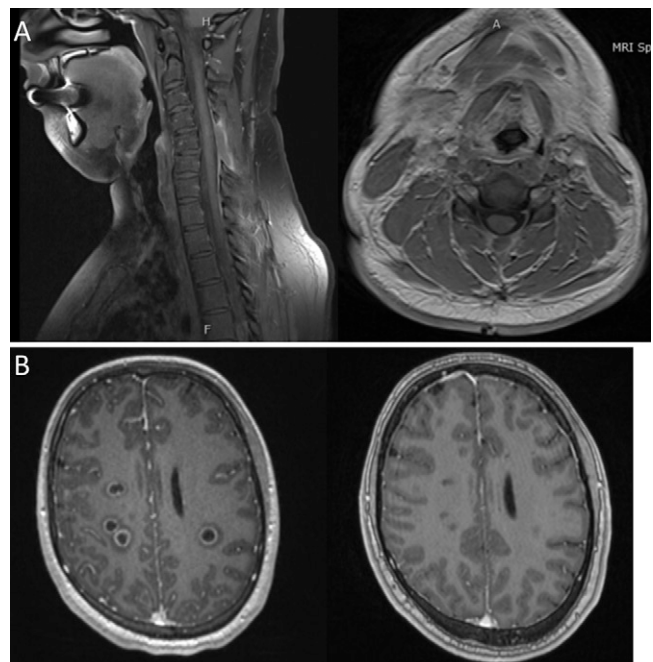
(A) Postoperative postcontrast T1-weighted MRI demonstrating minimal residual enhancement of the cervical cord. (B) Preoperative (left) and postoperative (right) axial postcontrast T1-weighted MRI demonstrating complete resolution of brain abscesses with resultant gliotic scars.
